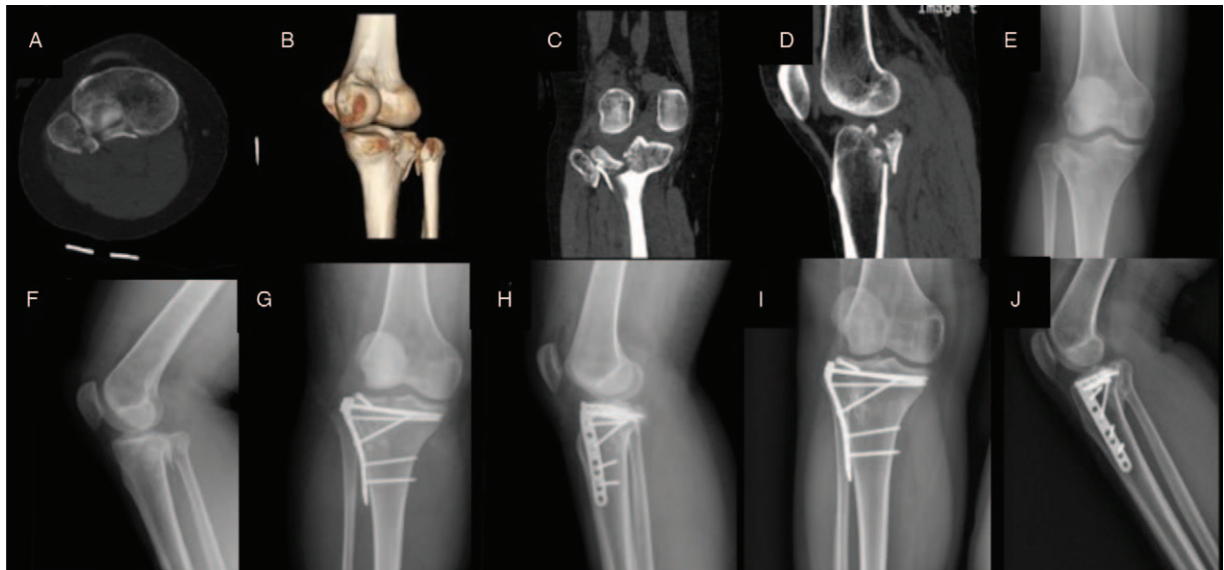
A female Schatzker type II patient, 28 years old, with a right tibial plateau fracture (Schatzker type II) and fibular head fracture due to a traffic accident injury. Pre-operative X-ray and CT cross-sectional, coronal, and sagittal reconstruction showed that the fracture line involved the posterior and lateral columns (A–F). The extended anterolateral approach involved L-shaped plate plus auxiliary screw fixation. Immediate postoperative X-ray (G, H) showed that anatomical reduction was achieved. Fifteen months after the operation, X-ray (I, J) showed an articular surface without depression and no increase in the width of the tibial plateau. CT = computed tomography.
